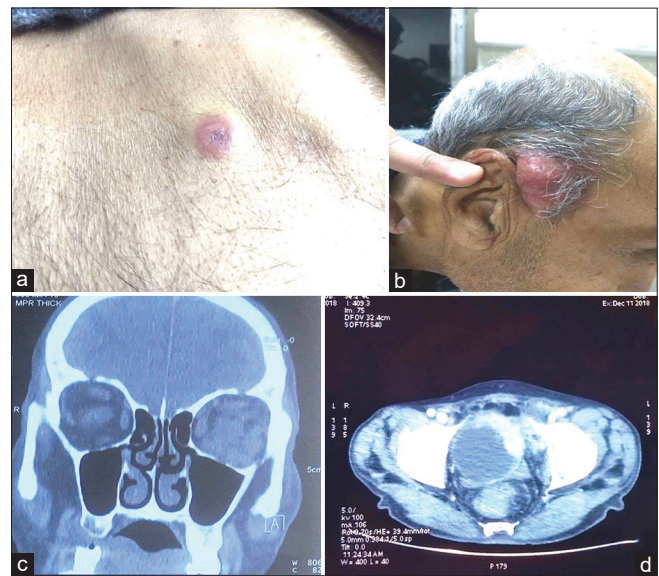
(a) Skin nodule on the right upper abdomen. (b) Skin nodule on the scalp above the right ear. (c) Computed tomography of the orbit showing soft tissue thickening in the left orbit (d) Axial section of contrast-enhanced computed tomography scan showing heterogeneously enhancing urinary bladder mass
